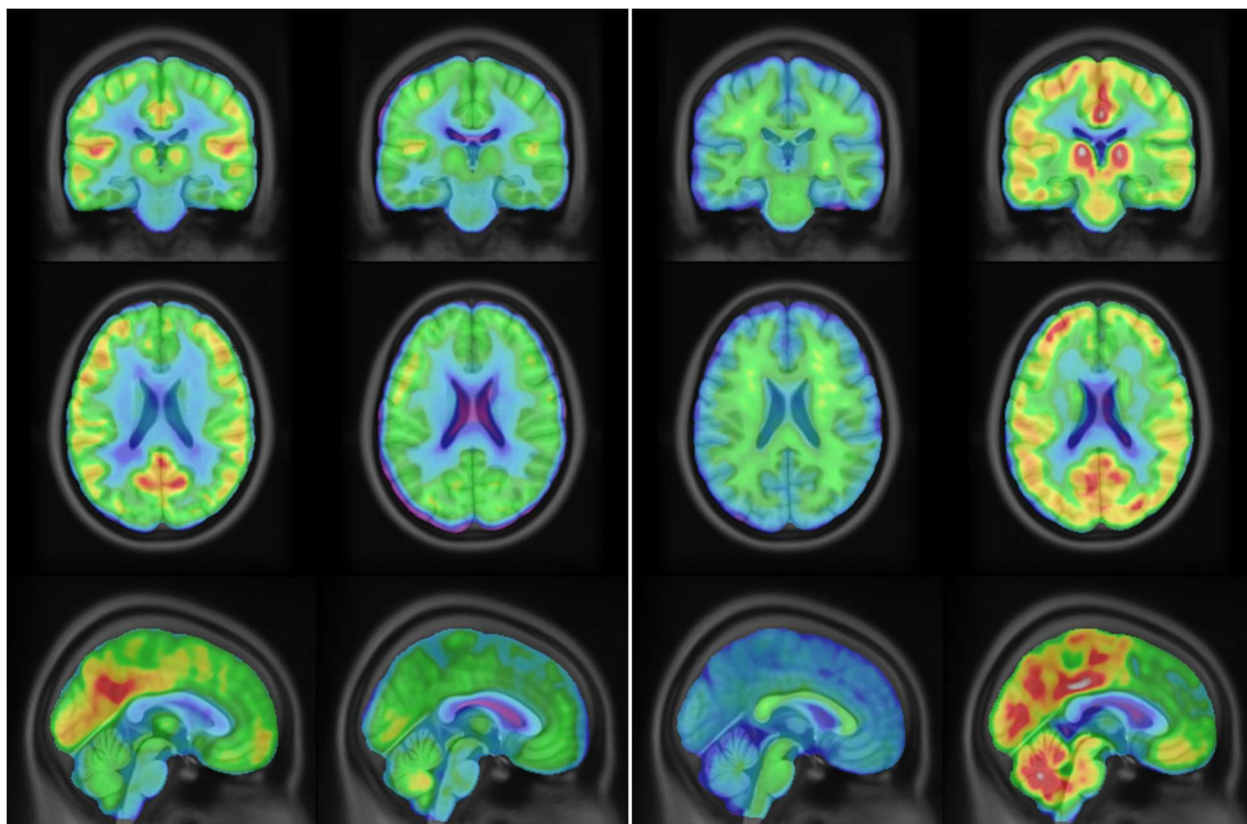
Column 1 is a normal ^{18}F -FDG scan. Column 2 is an abnormal ^{18}F -FDG scan. Column 3 is a normal amyloid scan using Florbetapir. Column 4 is an abnormal amyloid scan using Florbetapir.
